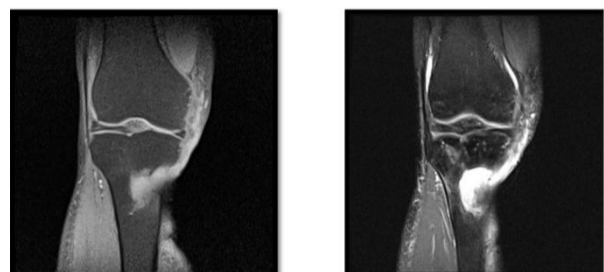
MRI of the knee with hyposignal and hypersignal images in T1 and T2 respectively.
